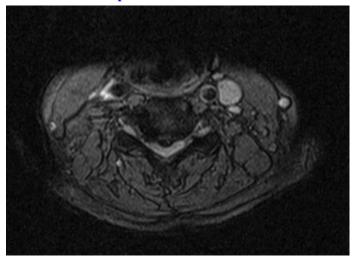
Axial T2 weighted MRI examination at the level of C4-5 showing severe compression of the spinal cord causing advanced spondylotic cervical myelopathy.
